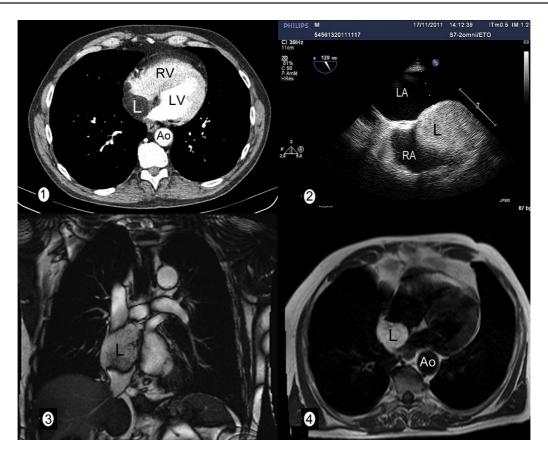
1. Computed tomography scan of the chest. 2. Transesophageal echocardiography transverse view 120°. 3. CMR image: SSFP sequence in the coronal view. 4. CMR image: black-blood T1-weighted spin echo in the transverse view. Ao: aorta; L: lipoma; LA: left atrium; LV: left ventricle; RA: right atrium; RV: right ventricle.
